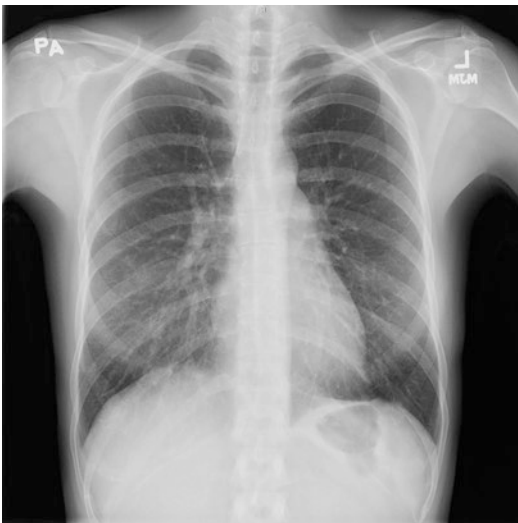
Chest X-ray imaging of a patient with carmustine pneumonitis, showing bilateral interstitial pneumonitis
